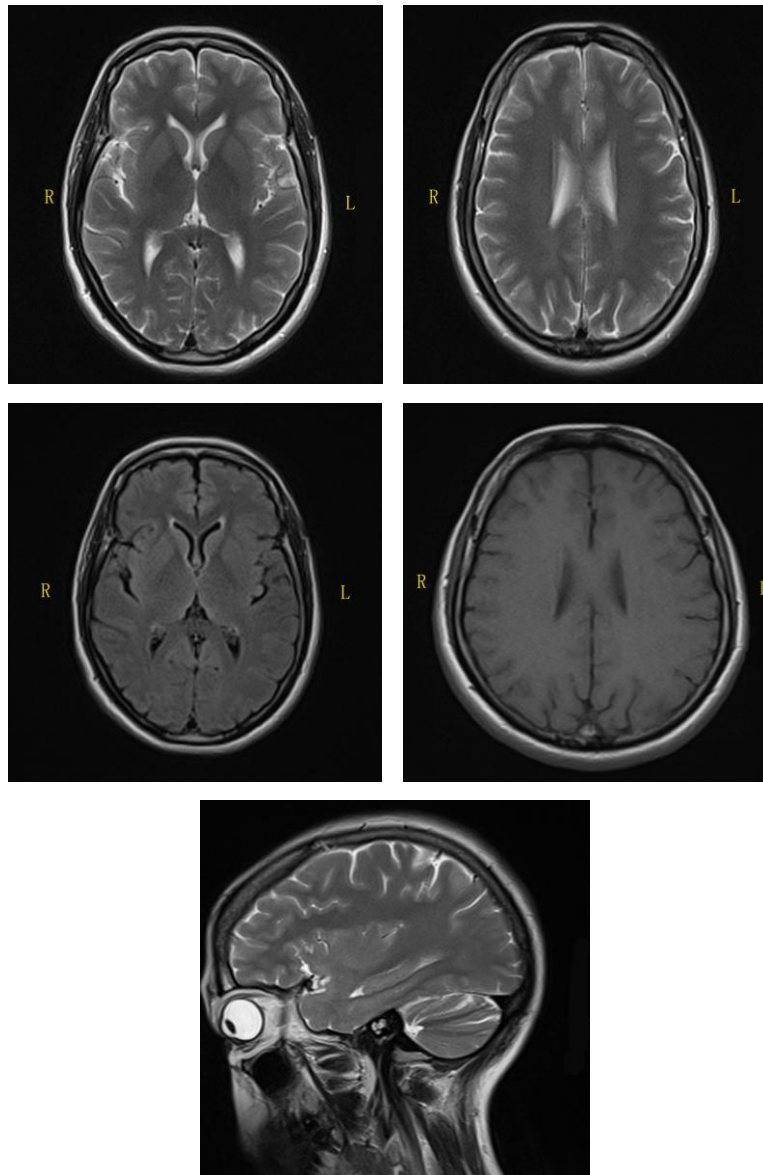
Brain magnetic resonance images of a patient with heroin-induced spongiform leukoencephalopathy following 12 months of home-based rehabilitation demonstrating almost complete resolution of bilateral abnormalities in the cerebral white matter. R: Right; L: left.
